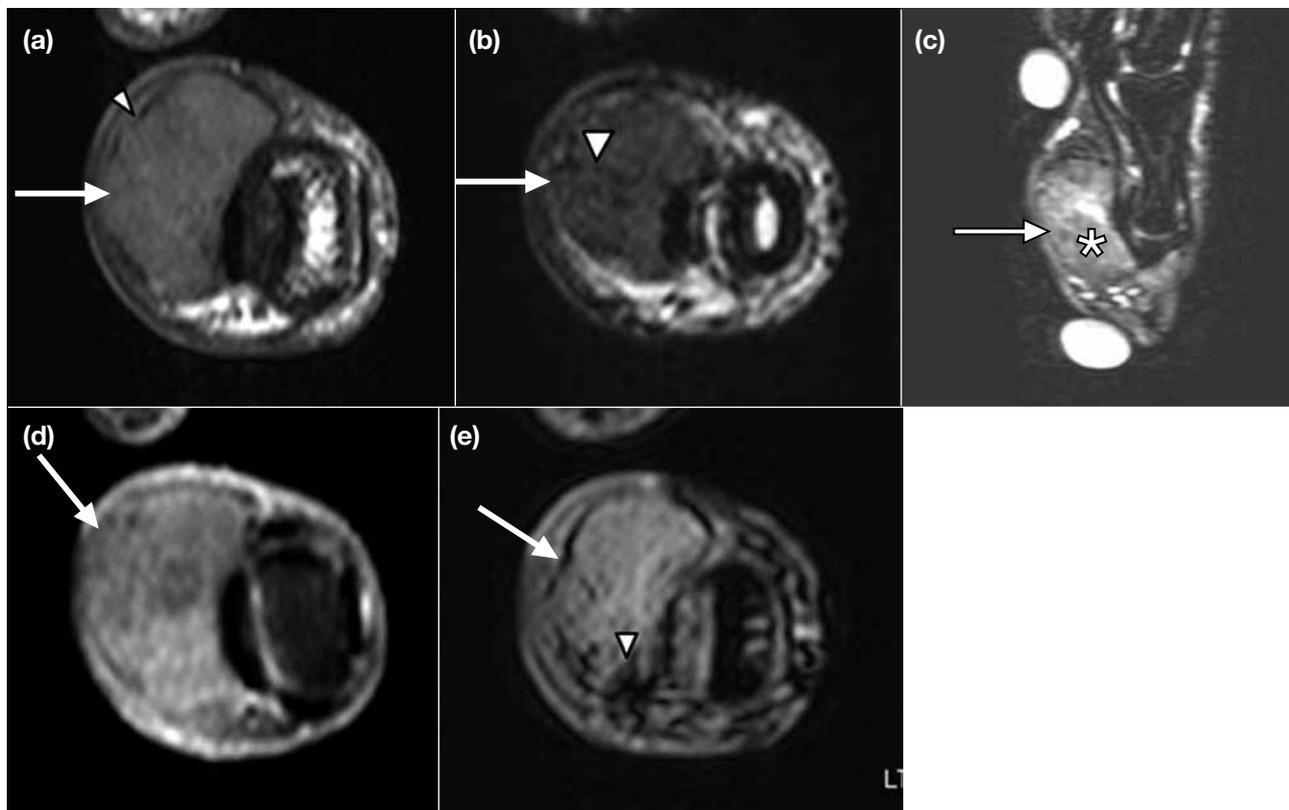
A 66-year-old man with giant cell tumour of the tendon sheath at the volar aspect of the middle finger. (a) An axial turbo spin-echo (TSE) T1-weighted magnetic resonance image (MRI) (TR/TE = 504/20) shows a well-marginated homogeneous oval soft tissue mass (arrow) with intermediate signal intensity. It has discontinuous low signal intensity capsule (arrowhead). (b) An axial TSE T2-weighted MRI (TR/TE = 3314/100) shows the soft tissue mass (arrow) is inhomogeneous and of low signal intensity. Thin septations are seen within the tumour (arrowhead). (c) A sagittal T2-weighted image with fat suppression (TR/TE = 4607/70) shows the soft tissue mass (arrow) is of high signal intensity and inhomogeneous with intermingling areas of low and intermediate signal intensity (asterisk). (d) An axial TSE T1-weighted image with fat suppression after gadolinium contrast (TR/TE = 550/20) shows avid enhancement of the soft tissue mass (arrow). (e) An axial T2-weighted gradient-echo image (TR/TE = 550/8.1) shows inhomogeneous intermediate signal intensity mass (arrow) with blooming artefact of low signal intensity foci (arrowhead) due to the presence of hemosiderin deposit.
